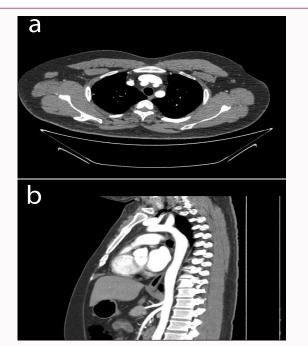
CTA of the chest showing resolution of the previously seen filling defect within the origin of the left subclavian artery.
